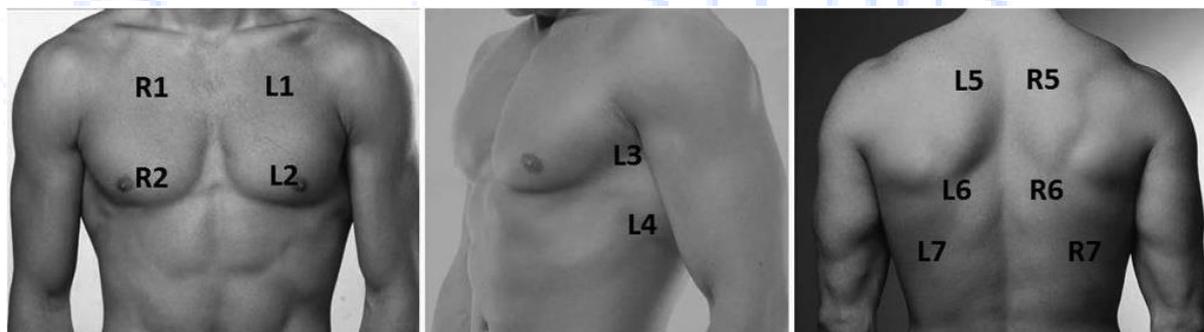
The layout of the sensor during ultrasound examination of the lungs using the BLUE protocol
